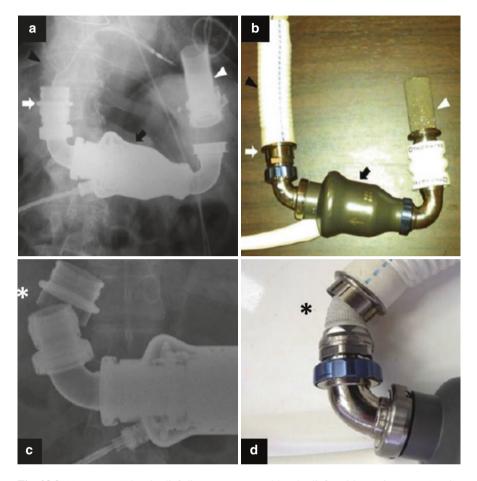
HeartMate II bend relief disconnect. Normal bend relief position (*white arrow*) at its insertion point between the outflow graft (*black arrowhead*) and the LVAD pump (*black arrow*) as demonstrated by an abdominal x-ray (a) and photo (b). Inflow cannula marked by *white arrowhead*. Abdominal x-ray (c) and photo (d) of a full bend relief disconnection [40]
